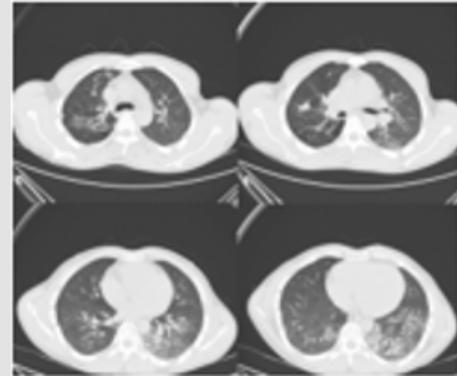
Thorax CT, ground-glass areas with band formations and mild consolidation.
